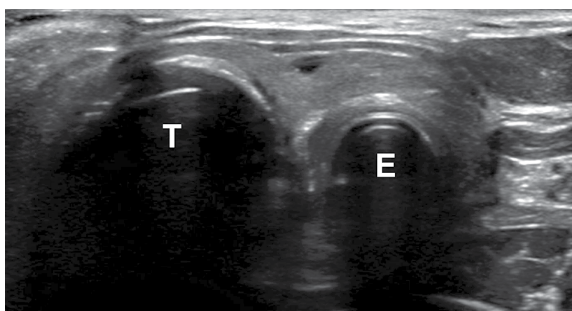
Esophageal intubation on point-of-care ultrasound. Endotracheal tube visualized as a thin, hyperechoic line within esophagus (E) that is distended and creates appearance of second trachea located laterally to actual trachea (T)
